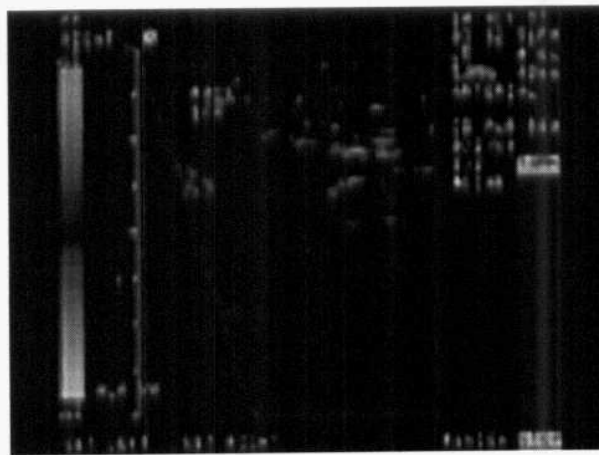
absence of color Doppler (*Burns PN. 1995b*)
